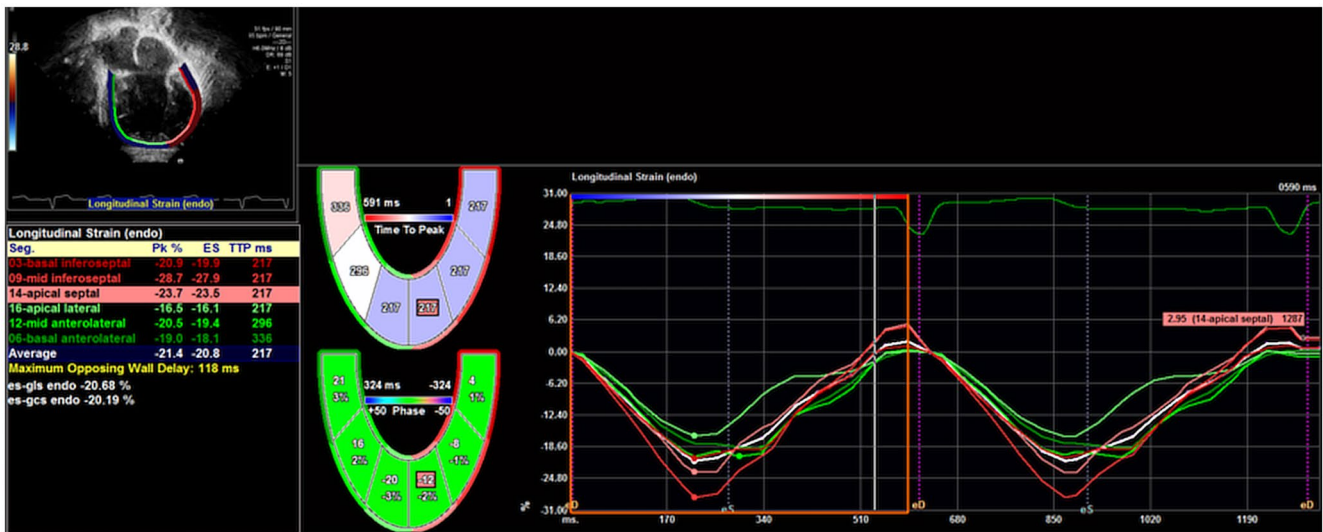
Example of a longitudinal deformation echocardiogram tracing. This image of the single ventricle was obtained in the apical view. Strain obtained in each segment (color coded) and also averaged into a global strain, seen in the bottom left. Waveforms of the strain during cardiac cycle is also included in the bottom left
